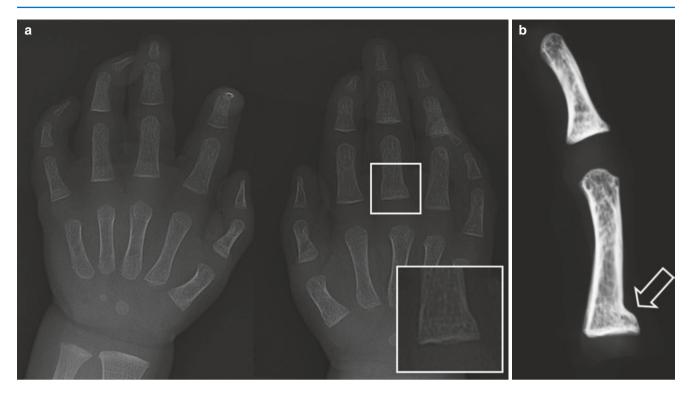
Four-month-old sibling of an abused index case. (a) Radiograph of the left hand shows slight irregularity and subperiosteal new bone formation at the base of MC-III (inset). (b) AP radiograph of the right knee shows a metaphyseal corner fracture of the proximal tibia
